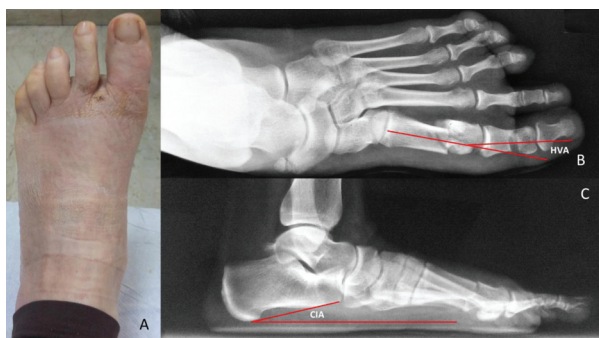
Post-operative assessment of a 40-years old patient. A Post-Operative Clinical photograph showing hallux valgus correction after bandage removal; B Pre-operative X-ray showing Hallux Valgus Angle(HVA) of 12°; C Pre-operative X-ray showing Calcaneal Inclination Angle (CIA) of 11°
